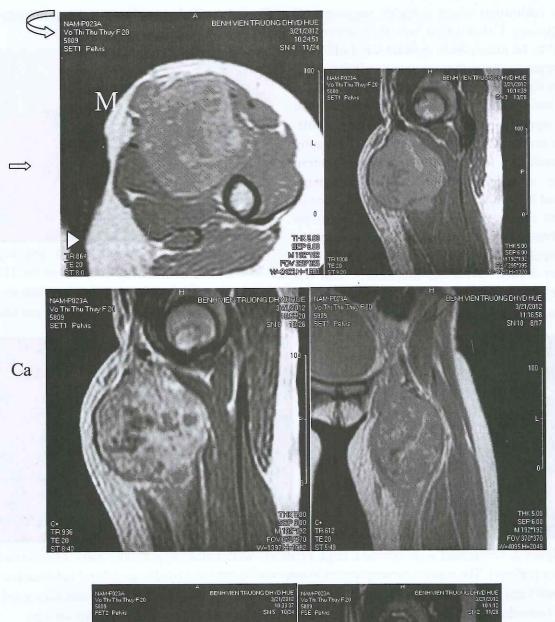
Sagittal and coronal T1 weighted MR images show a 8x9x10 cm well-defined, heterogeneous soft tissue tumor (M) which is hypo-to-intermediate signal intensity in the anterior left upper thigh with extensive subcutaneous tissue invasion (IN). Intravenous contrast-enhanced T1W shows heterogeneous predominant enhancement of the mass, reflecting the intermixture of nonenhancing necrotic, cystic or hemorrhage, and enhancing solid regions. On T2-weighted image, the mass contains strikingly hyperintense cystic areas (star) with irregular septa of intermediate signal intensity. Arrows indicate edema of the adjacent tissue. Note the peripheral rim of hypointensity on both T1 and T2 weighted images represent calcification (Ca) which is proved on X ray.
